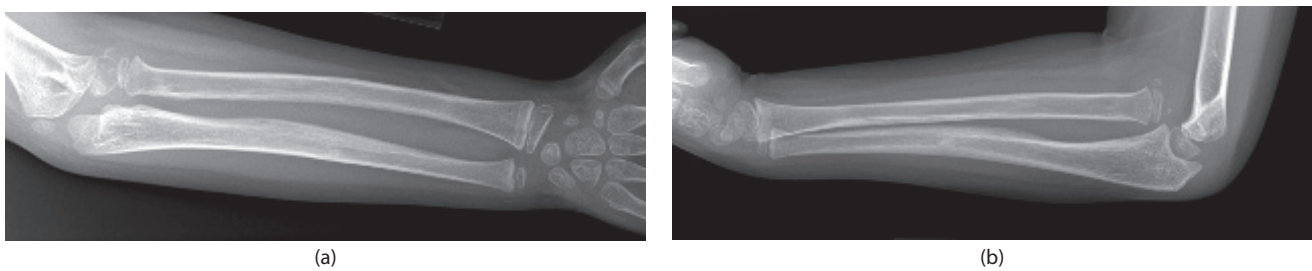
(a, b) AP and lateral forearm x-rays reveal a chronic Monteggia fracture-dislocation. The radial head is anteriorly displaced and there is a healed ulna fracture. The dislocation of the radial head was not originally appreciated.
